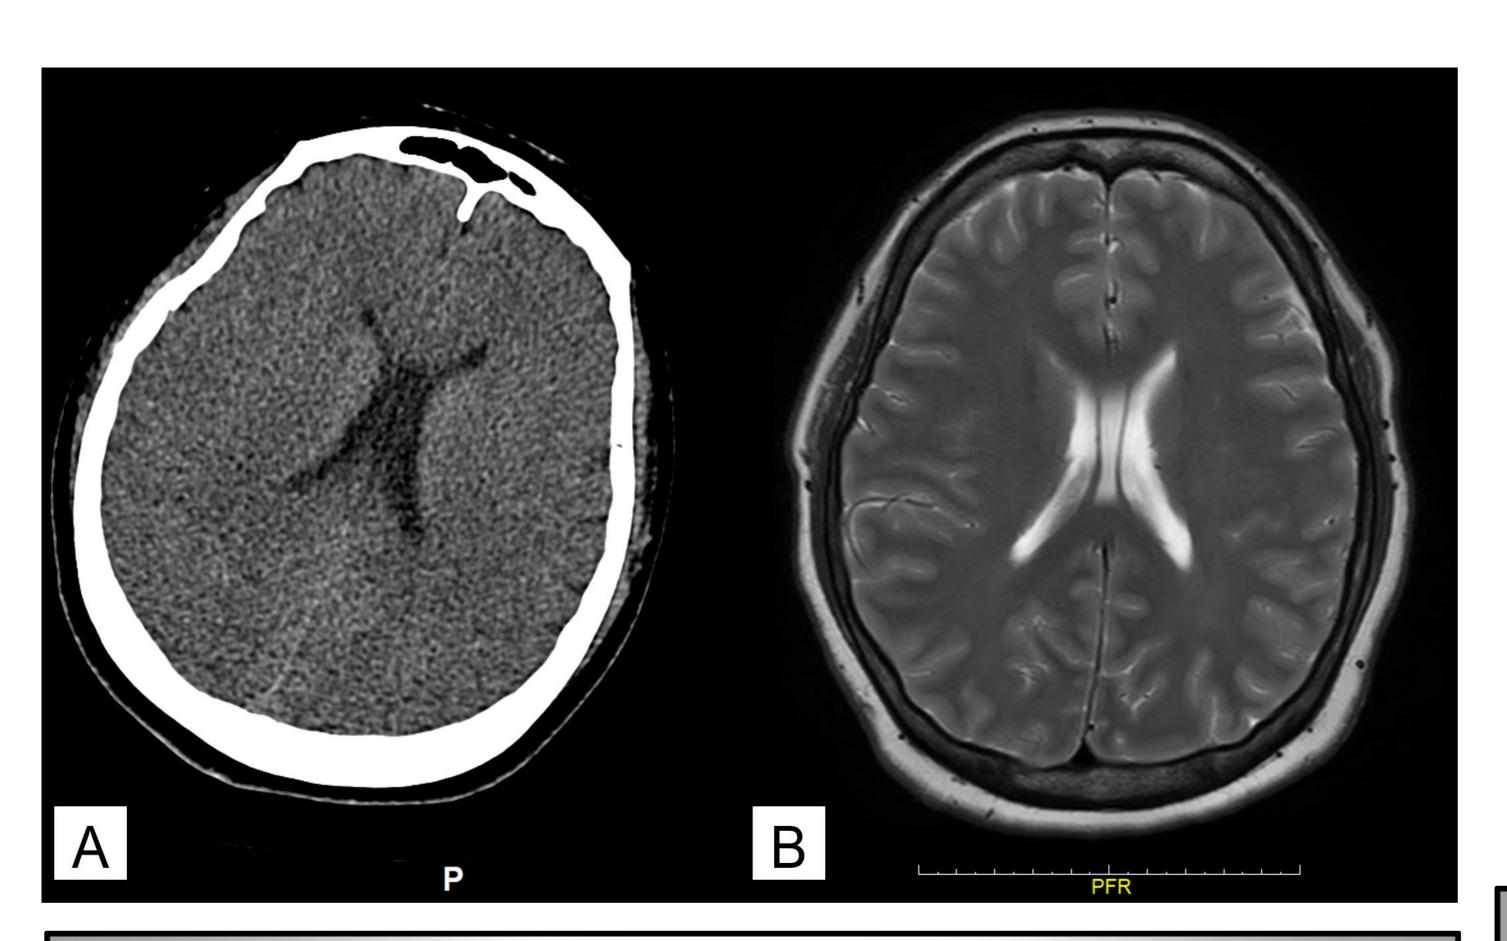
(A) Preoperative Brain CT scan shows no hemorrhagic lesion or visible causes of the seizure. (B) Preoperative Brain MRI also shows non-specific findings.
